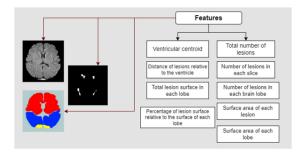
Example of Features extracted from MRI Images.
